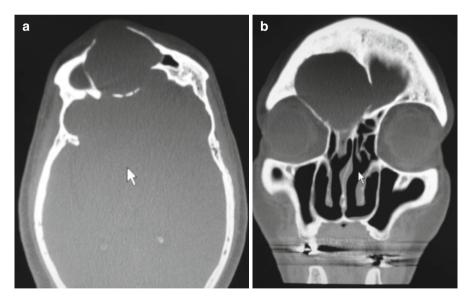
(a, b) Axial and Coronal CT scan images with orbital wall expansion and both anterior and posterior table frontal sinus erosion
